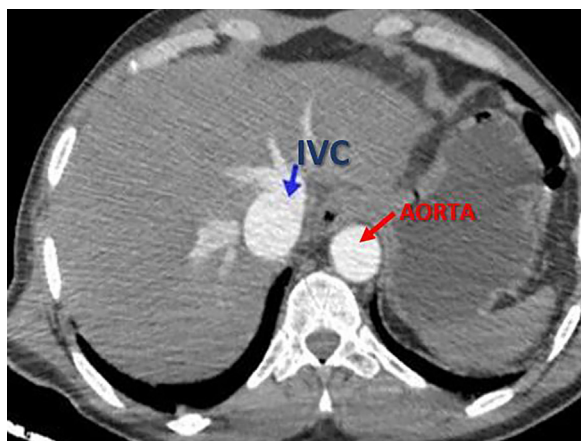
CT Angiographic at arterial phase in axial section showing dilatation with simultaneous opacification of IVC and aorta in arterial phase.
